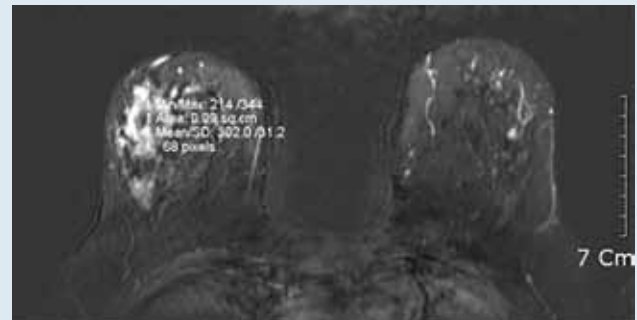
(Top Panel) and 3b (Bottom Panel. Subtracted postcontrast MRI showed non-mass lesion of the right breast, with clumped internal enhancement and regional distribution. Dynamic-kinetic curve with ROI inside non-mass lesion had rapid enhancement in initial phase with plateau in the delayed phase. Second-look US guided core needle biopsy revealed atypical ductal hyperplasia. Suspicious imaging findings indicated wide open surgical excision - multifocal DCIS was revealed. Subsequent mastectomy was performed, and microinvasive ductal carcinoma was proven.
